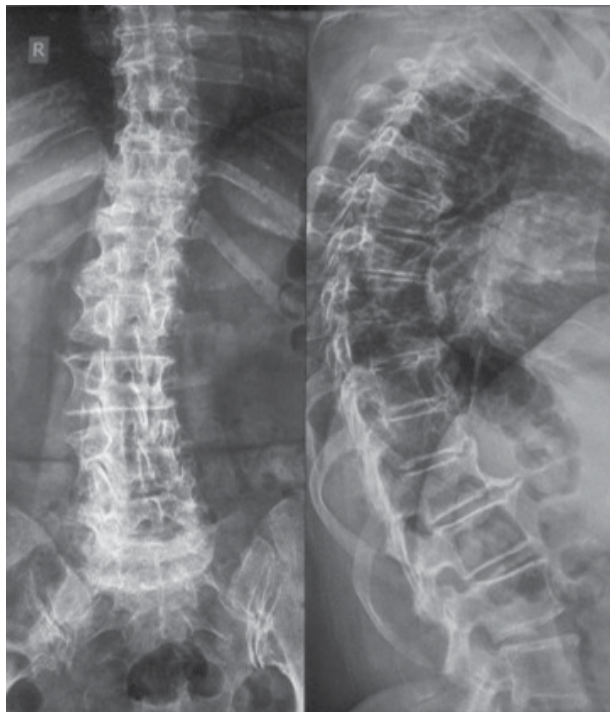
Radiographic images: posterolateral and lateral view of the spine preoperatively (A) and postoperatively (B).
